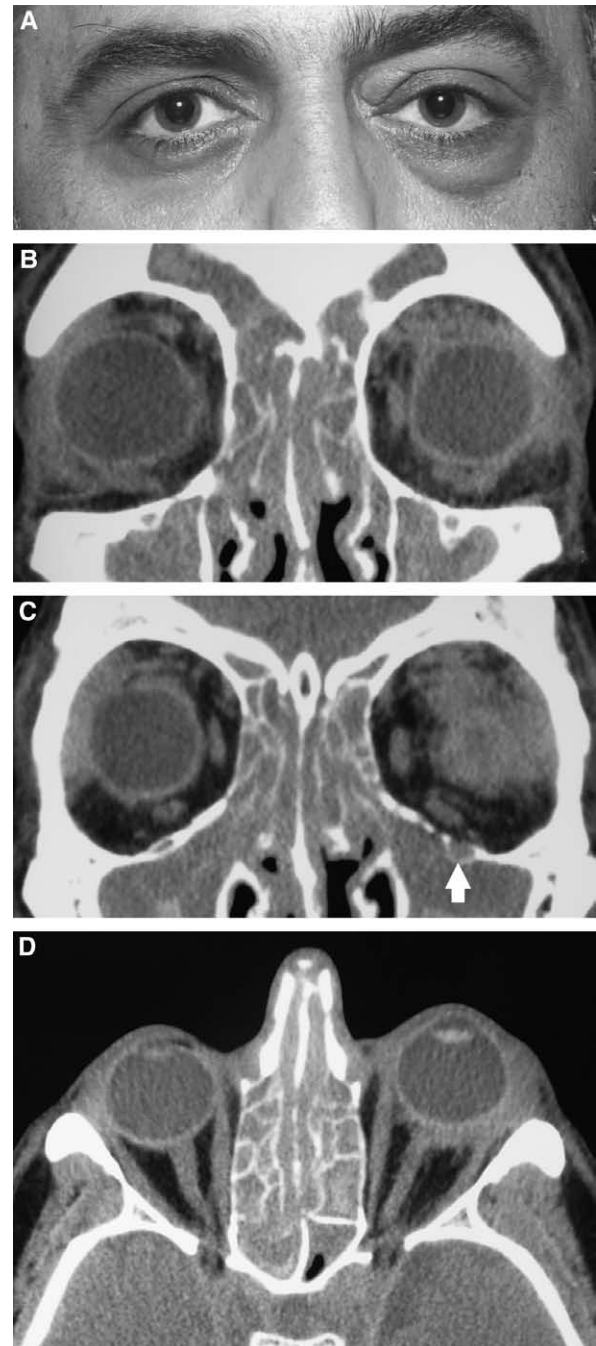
Case 3. Bilateral, asymmetric lacrimal gland and orbital fat disease, rhinosinusitis, on background of sclerosing cholangitis. A, A 41-year-old man presented mid 2009 with 5 months swelling in the left lacrimal gland and chronic rhinosinusitis. He had recently developed grossly deranged liver function tests and was found to have autoimmune sclerosing cholangitis, and grossly elevated serum IgG4 levels of 19.8 g/l ($N < 0.86$ g/l). B, C, and D, Coronal and axial CT scans show pansinusitis and poorly defined enlarged lacrimal glands with an infiltrative process spilling over into the orbital fat. In (C), there is possible enlargement of the infraorbital nerve (arrow). Biopsy of the left lacrimal gland showed chronic sclerosing dacryoadenitis with large numbers of IgG4+ plasma cells and a ratio of IgG4+/IgG+ plasma cells of 41%. He was treated with oral steroids, with improvement in his orbital and nasal symptoms and normalization of liver function tests, but relapse on tapering of the oral steroids, treated with Azathioprine and low dose steroids.
